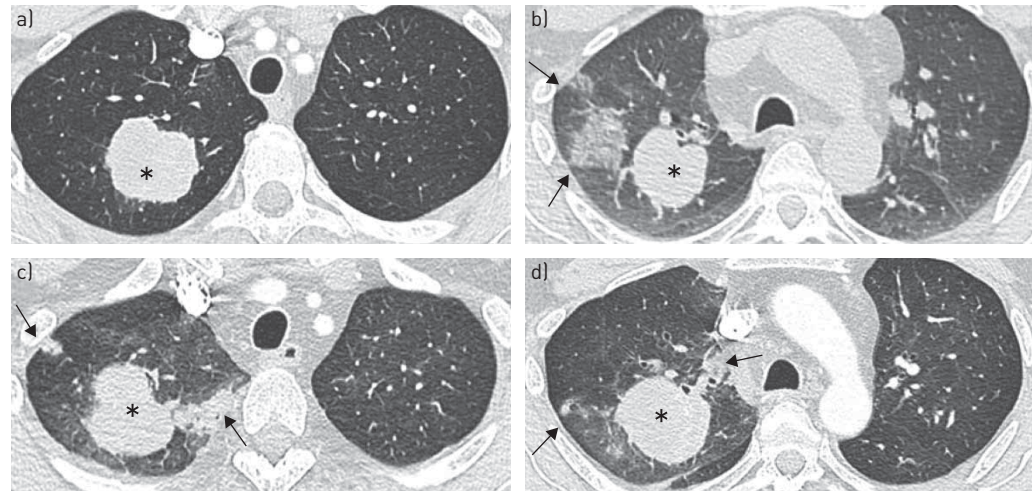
Immune-related pneumonitis grade 1 with organising pneumonia features developed after two cycles of combined therapy with nivolumab and ipilimumab in a 46-year-old man with metastatic melanoma. a) Lung metastasis (*) of the right upper lobe on baseline computed tomography (CT) scan. b) The restaging CT performed after the first cycle shows a focal area of ground-glass opacity (arrows) in the vicinity of the lung metastasis (*). The patient was asymptomatic. c and d) 1 month later, the ground-glass opacity has disappeared but new-onset subpleural and peribronchovascular consolidations (arrows) are seen close to the metastasis. No CT abnormalities are found in the contralateral lung.
